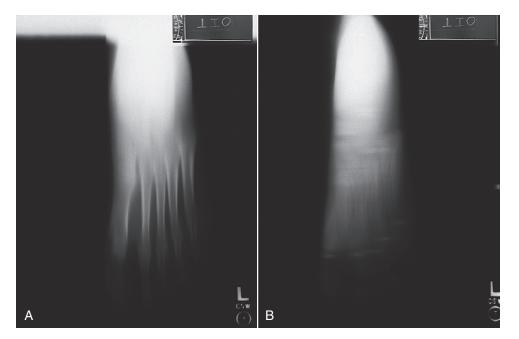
Foot tomographs obtained with x-ray tube motion. A, Parallel to the body axis. B, Perpendicular to the body axis. (Courtesy Rees Stuteville, Oregon Institute of Technology.)
